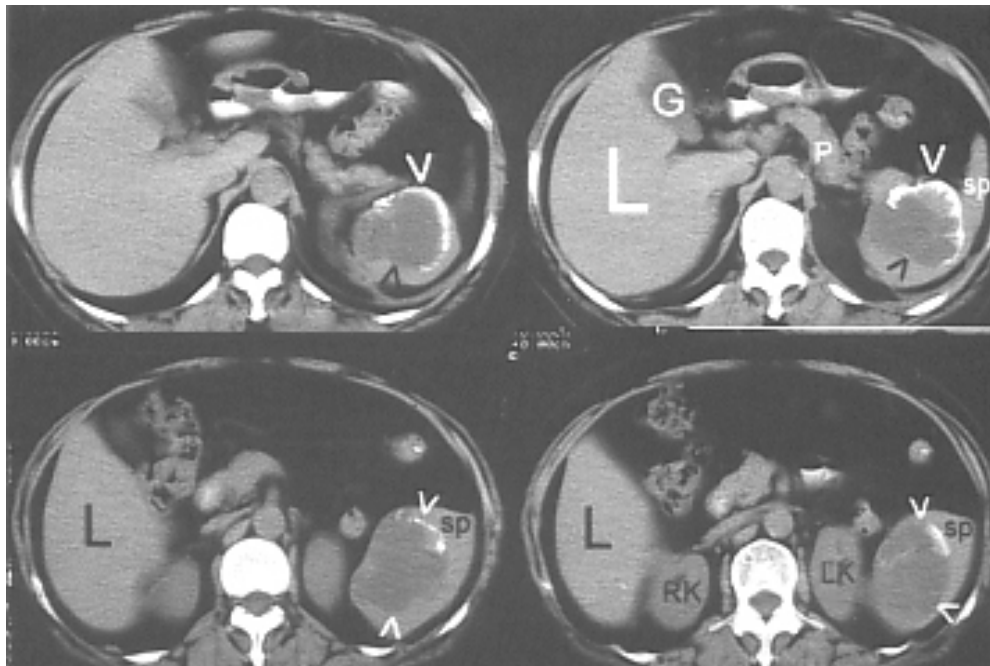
A series of abdominal CT of the patient shows an 8-cm low density mass (small arrowhead) with peripheral calcifications (large arrowhead) and internal septa in the spleen. SP: spleen; L: liver; G: gallbladder; RK: right kidney; LK: left kidney; P: pancreas
